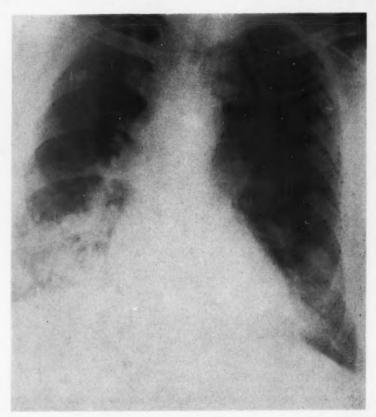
Case 11. Bedside chest x-ray, 9/6/55. X-ray report: "Generalized density over both bases through which we see accentuated vessel markings . . . we are dealing mainly with pulmonary congestion." Pleural fluid not mentioned.
